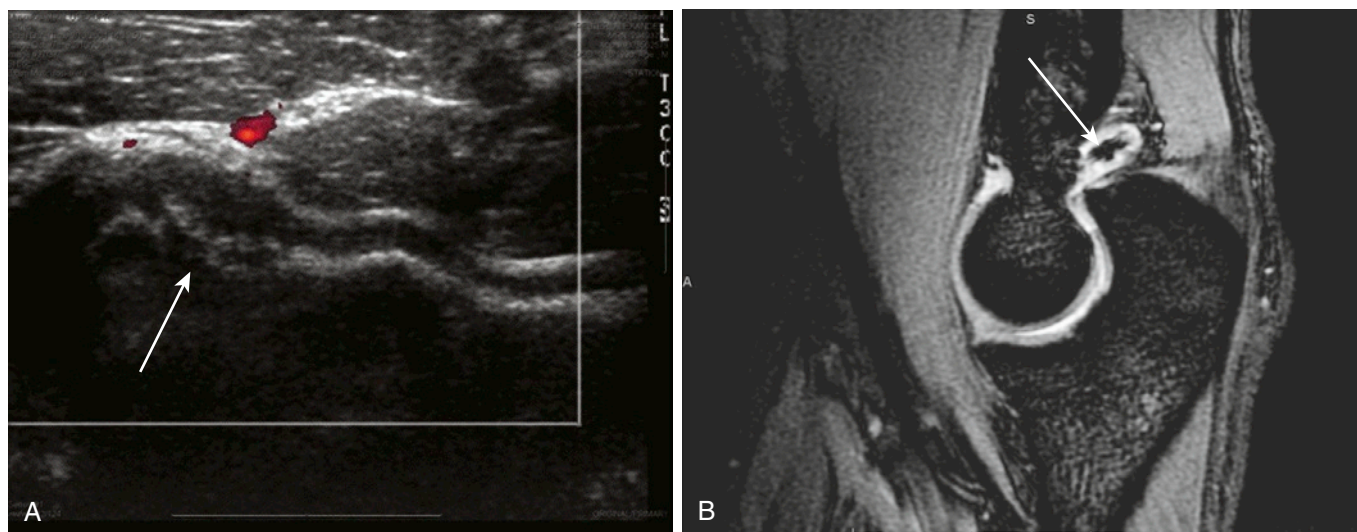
A, Cartilage defect, Panner's lesion, in a 16-year-old, with a resultant loose body (arrow) in the olecranon fossa. B, Follow-up MRI.
